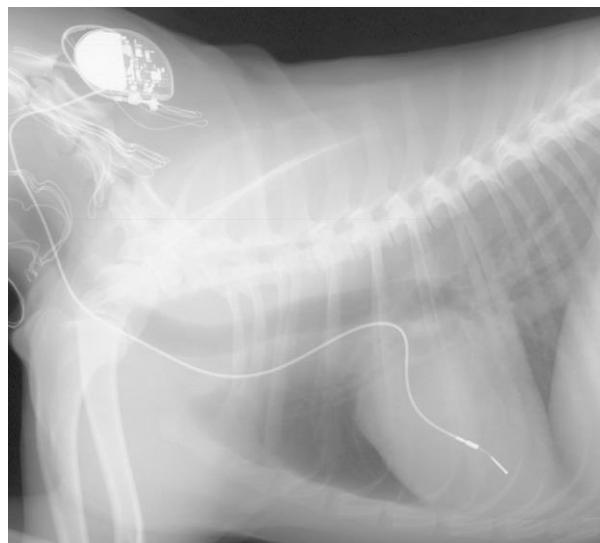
A left lateral thoracic radiograph showing placement of a pacing catheter with a bipolar electrode in contact with the right ventricular apical endocardium and a generator placed under the skin on the neck
